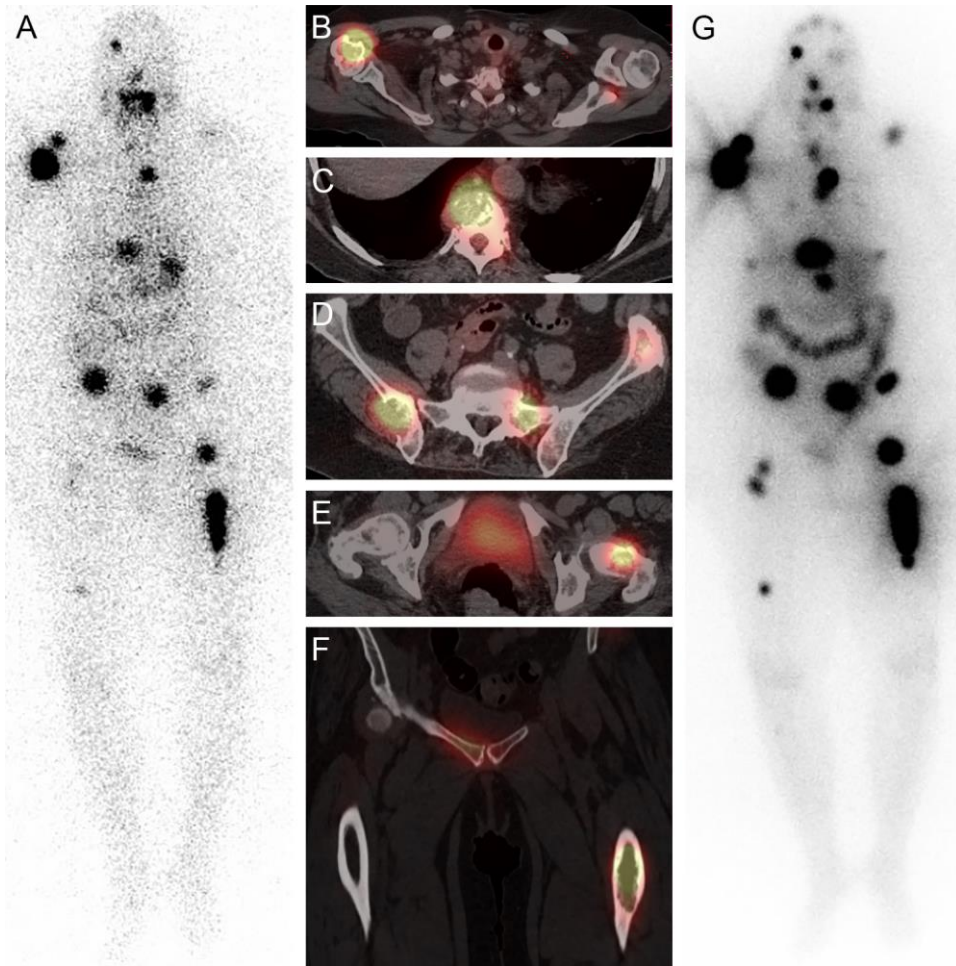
Radioiodine theranostics for a 66 year-old-woman with 2.5 cm widely invasive FTC with osseous metastatic disease. Diagnostic 1 mCi  $^{131}\text{I}$  WBS, anterior projection (A) depicts multifocal skeletal activity further characterized on SPECT/CT as iodine-avid lytic osseous metastases involving the right humerus (B), vertebrae (C), pelvis (D) left femoral neck (E) and left femoral diaphysis (F). The patient received dosimetry-guided 12 GBq (325 mCi)  $^{131}\text{I}$  treatment and post-therapy WBS, anterior projection (G) obtained at 2 days demonstrates therapeutic  $^{131}\text{I}$  targeting of extensive iodine-avid multifocal osseous metastatic disease involving the axial and proximal appendicular skeleton, with increased lesion conspicuity and numerous new foci detected as compared to the diagnostic scan.
